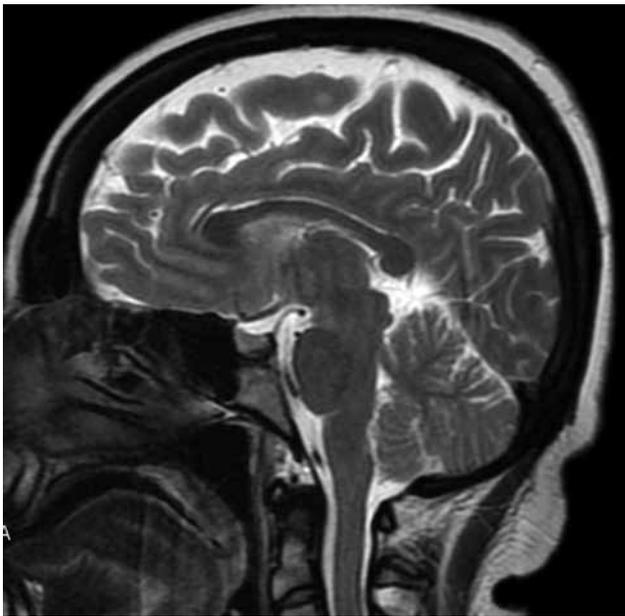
A T₂-weighted magnetic resonance imaging of a patient without no lesion in the brainstem.
